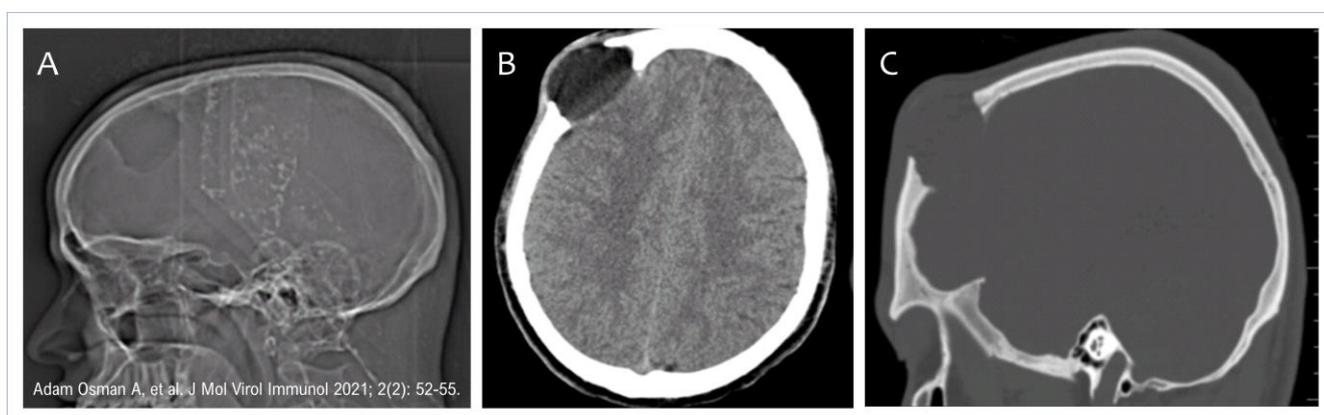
Lateral skull image (A) demonstrates the 4 cm diameter of a well-defined lytic lesion in the right frontal bone. The non-contrast axial and sagittal computed tomography scans of the brain (B, C) demonstrate a large calvarial defect in the right frontal lobe with a cystic lesion of the same density as the cerebrospinal fluid.
